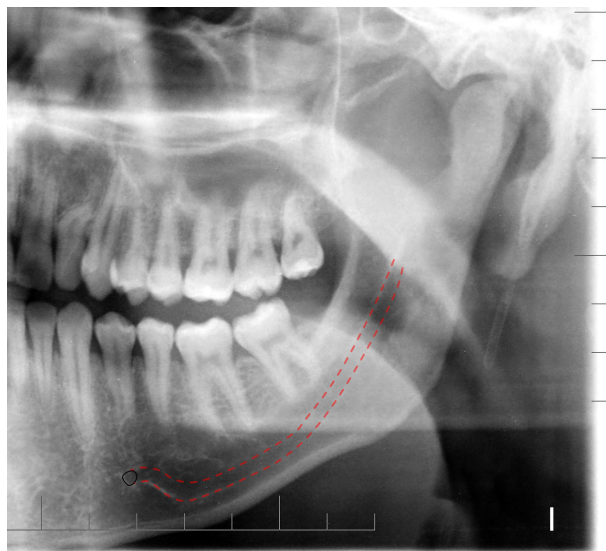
Radiographic image of the mandibular canal type 1 (red traces) in relation to the lower molars apices according Nortjé et al. (10) classification.
